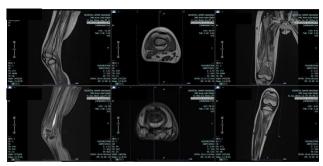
The MRI shows bilateral distal femoral subperiosteal hematoma with marrow and soft tissue edema.
